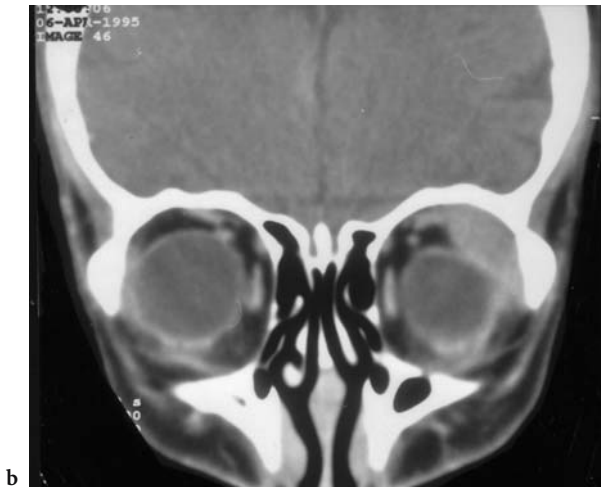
An 82-year-old woman with painless proptosis of the left eye persisting for 2 weeks. Diagnosis: non-Hodgkin lymphoma of the lacrimal gland. Contrast-enhanced CT: a Axial view with slightly enhancing mass of the left lacrimal gland, flattening the circumference of the left globe. c Corresponding coronal view where the extra-axial inferior dislocation of the bulb is more distinct than in a
